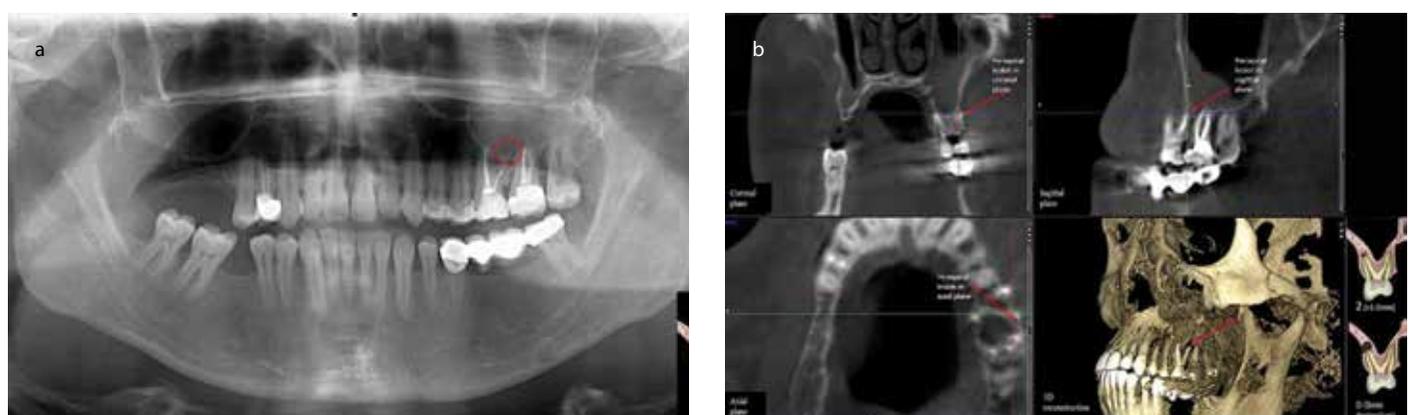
a, b. PAI scoring for tooth 26 using panoramic radiography: 1 (red circle) (a) CBCT-PAI scoring for the subject in Figure 2: coronal: 3+D, sagittal: 3+E, axial: 3+D (b)
